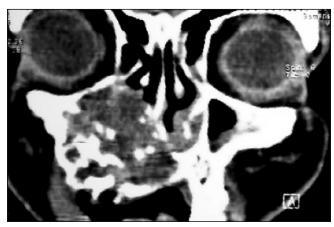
Coronal CT showing the extent of the tumor obliterating the full maxillary sinus and involving the nasal cavity on the right side
